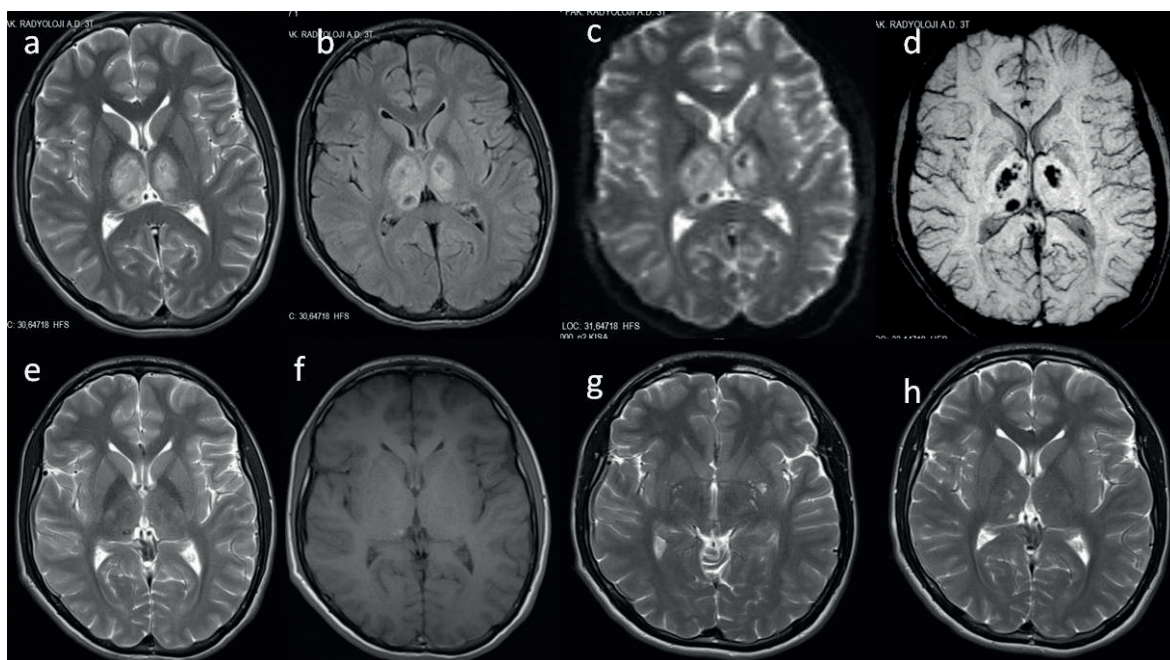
Dynamic changes of magnetic resonance imaging (MRI) of the case . (a) and, (b) and (c) were, respectively, the T2-weighted image(T2WI), fluid attenuated inversion recovery(FLAIR), and diffusion-weighted imaging(DWI) at onset which revealed symmetric, heterogeneous hyperintense signal changes on the thalamic nuclei, and decreased signal intensities in the center which are surrounded by increased signal intensities on the anterior thalamus, and (d)susceptibility-weighted imaging(SWI) at onset which showed multiple petechial hemorrhagic areas in thalamus. (e), and (f) were, respectively, the T2WI, and T1WI imaging at 22th day, which revealed gradually regression of edema and mass effect in both thalamic lesions. (g) and (h) were T2WI imaging of follow up at 18 months which showed mild sequelae and necrotic changes on bilateral thalamic nuclei.
